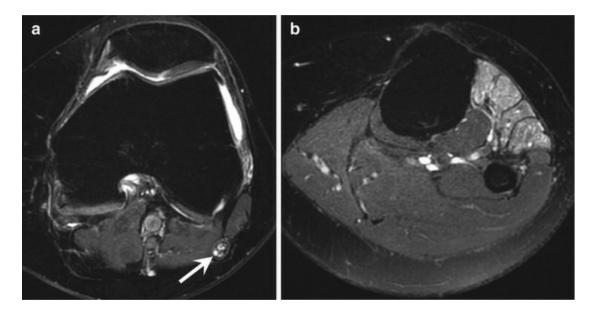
Idiopathic fibrosis and cystic degeneration of the common peroneal nerve. (a, b) Axial fat-suppressed T2-weighted MRI show an enlargement and a cystic degeneration of the common peroneal nerve (*arrow*) and edema of the tibialis anterior, extensor digitorum, extensor hallucis longus muscles
